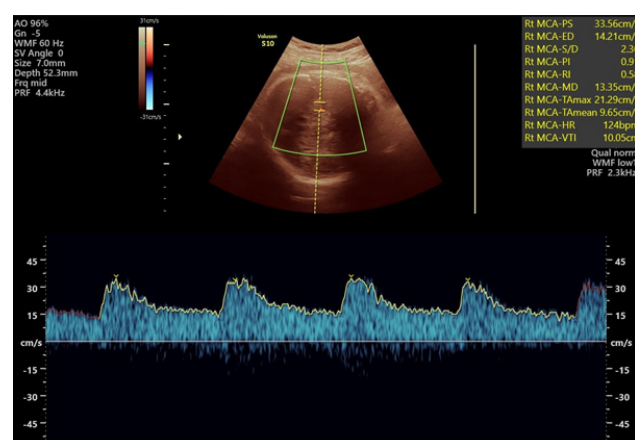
Abnormal MCA Doppler, MCA PI = 0.91, MCA RI = 0.5
